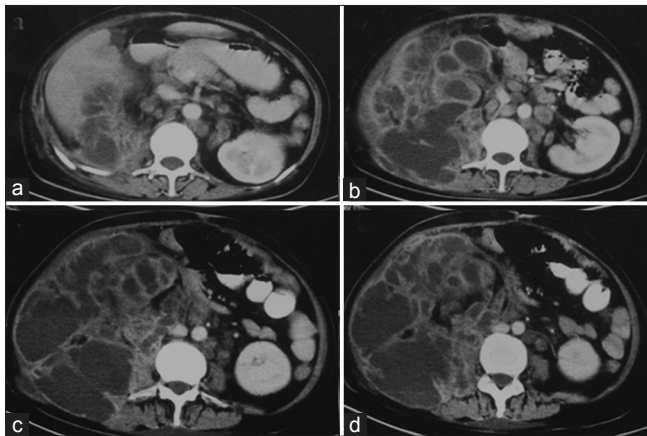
Contrast enhanced CT scan Abdomen shows poorly excreting right kidney with loss of contour and corticomedullary differentiation. Heterogeneous collection replacing the kidney with extension into right pararenal space, under surface of liver, pelvis and involvement of right Psoas, quadratus lumborum and lateral abdominal wall muscles. Also noted is retroperitoneal lymphadenopathy
